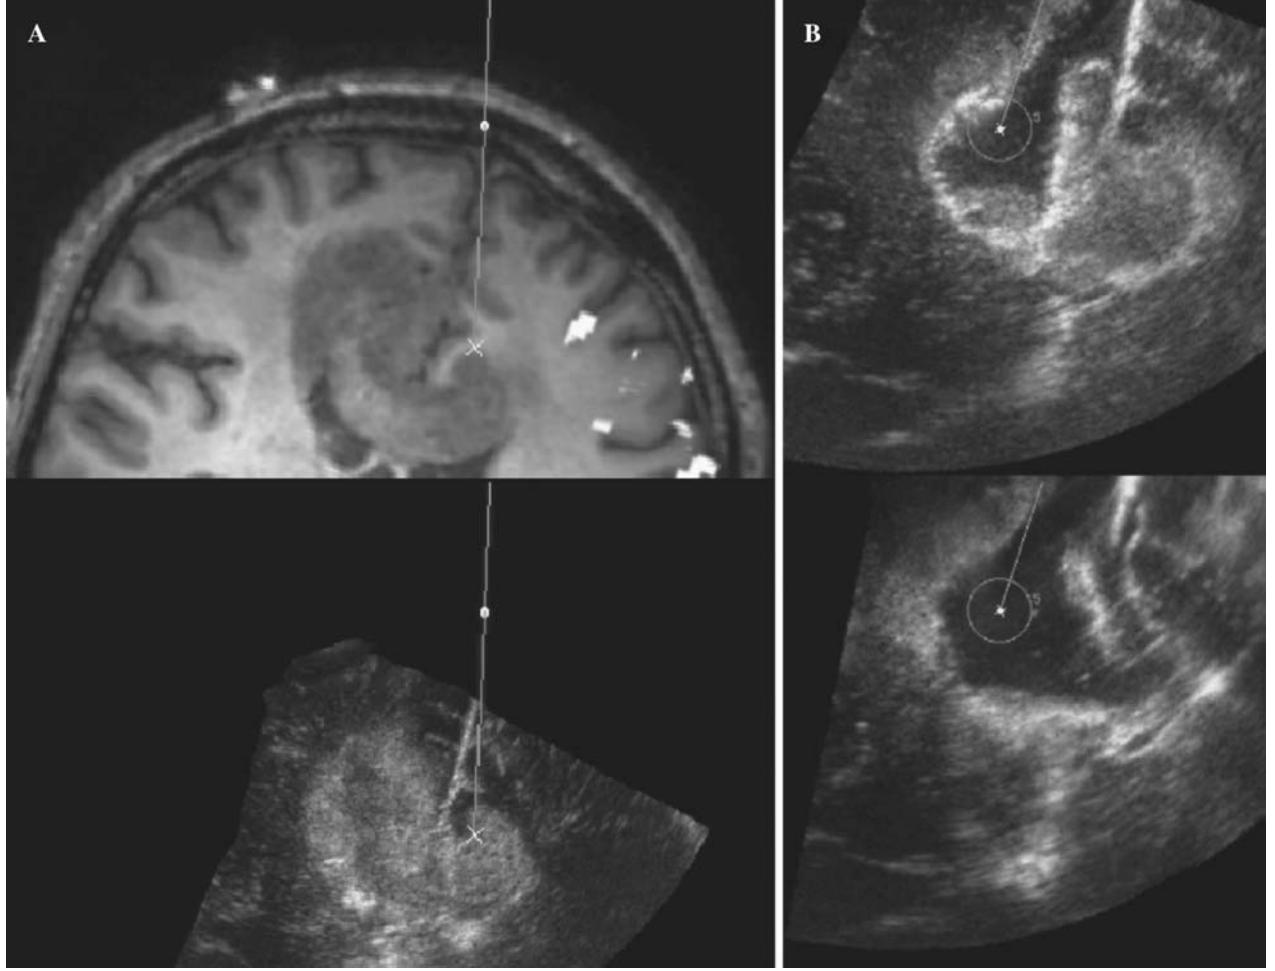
Intra-operative navigation and resection control (patient #2). (A) Corresponding anyplanes from MRI and ultrasound. The ultrasound data had been acquired from dura before surgery had started. (B) Later in the operation CUSA navigated resection was performed based on intra-operative ultrasound alone as the MR data became inaccurate due to brain shift. The top ultrasound anyplane shows a small resection cavity, which is enlarged towards the end of the resection as shown in the bottom anyplane
